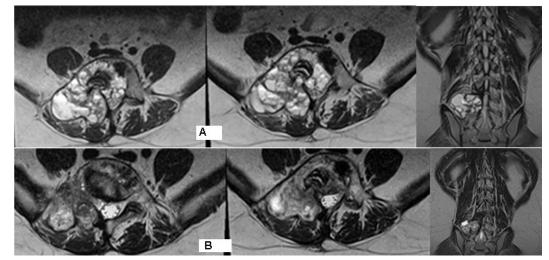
Comparison of MRI images before and after IMRT.
